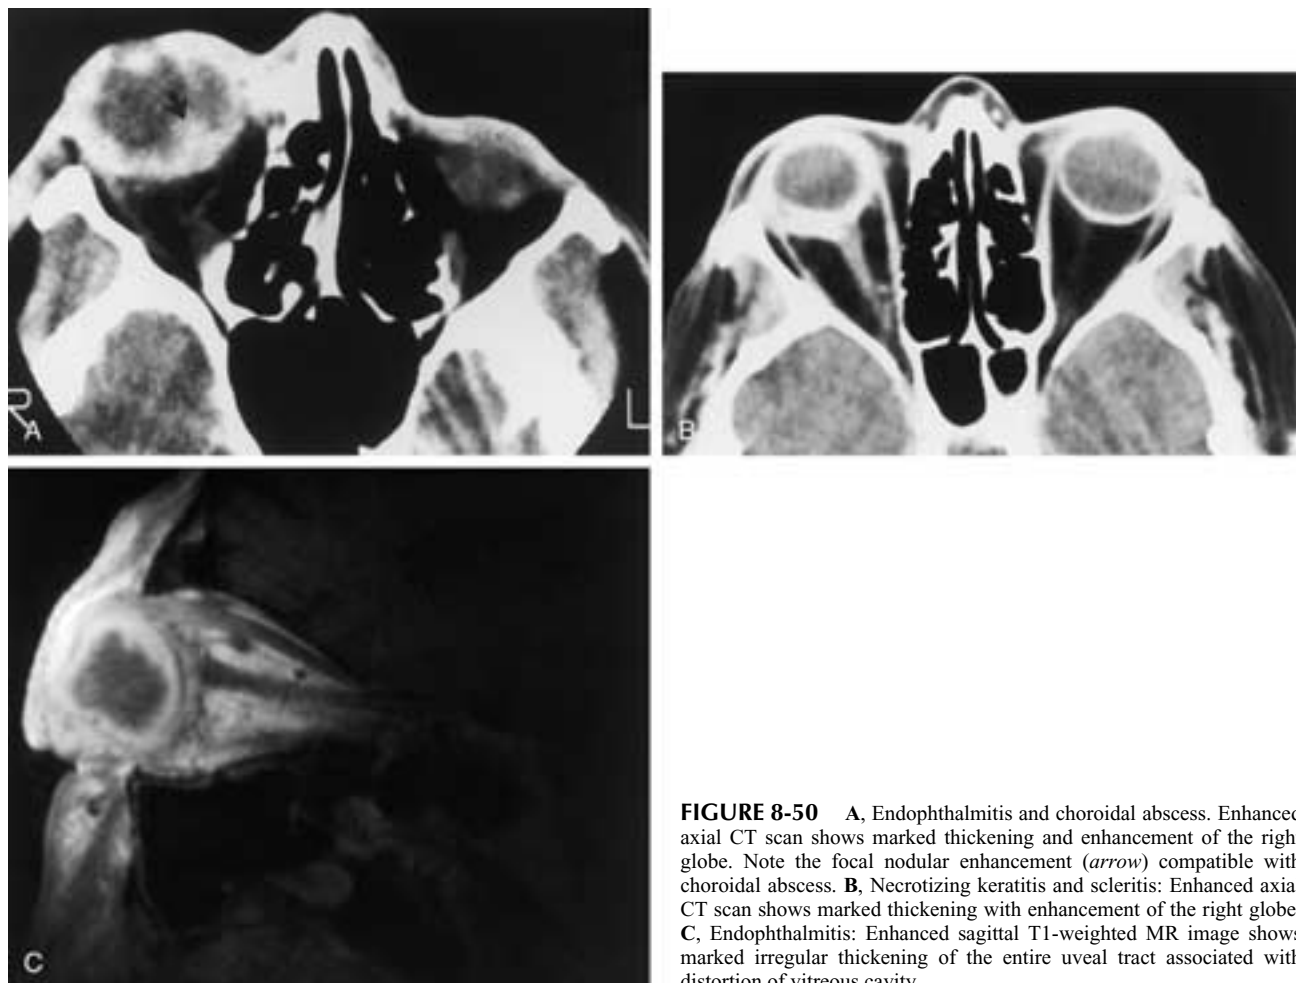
A, Endophthalmitis and choroidal abscess. Enhanced axial CT scan shows marked thickening and enhancement of the right globe. Note the focal nodular enhancement (*arrow*) compatible with choroidal abscess. B, Necrotizing keratitis and scleritis: Enhanced axial CT scan shows marked thickening with enhancement of the right globe. C, Endophthalmitis: Enhanced sagittal T1-weighted MR image shows marked irregular thickening of the entire uveal tract associated with distortion of vitreous cavity.
